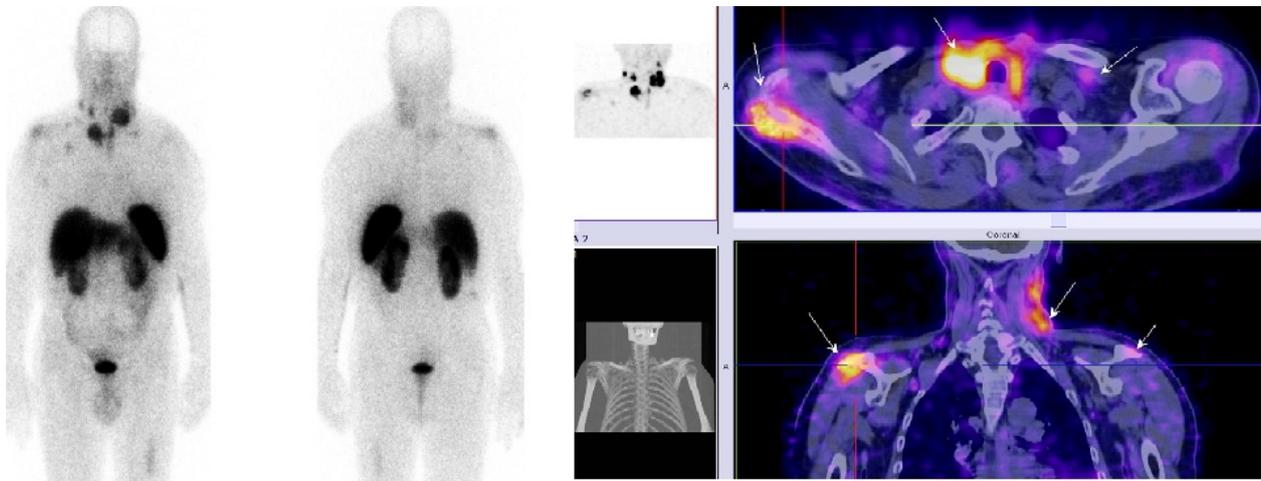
The same patient after target therapy with CAPRELSA/VANDETANIB/serum Calcitonin-1560 pg/ml in June 2016. Control whole-body scan followed by SPECT-CT showed reduced number and size of 60% of metastatic lesions-partial therapeutic response.
